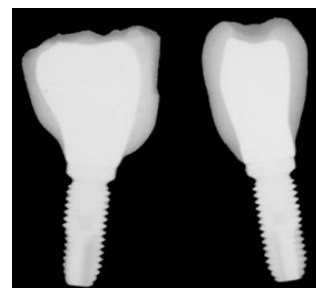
Post-mortem radiograph of the two single dental implants.
